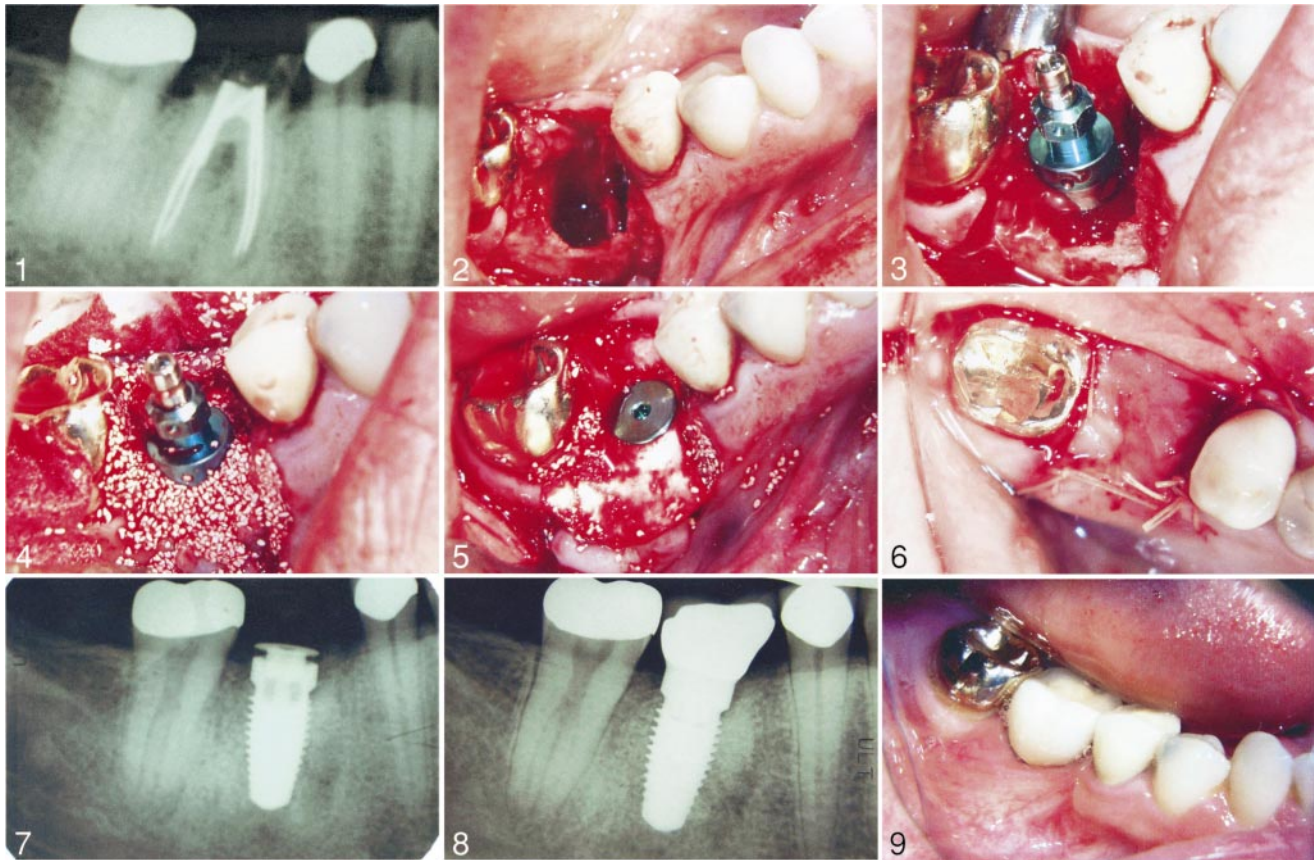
Radiographic view of case 1 preoperatively. FIGURE 2. Clinical view of the extraction socket after the extraction. FIGURE 3. Clinical view of the implant in place. FIGURE 4. Clinical view of the implant with the bone augmentation graft. FIGURE 5. The grafted material around the implant covered with the collagen membrane. FIGURE 6. The buccal and lingual flaps sutured. FIGURE 7. Radiographic view of the implant 3 months after the procedure. FIGURE 8. Radiographic view of the restored implant. FIGURE 9. Clinical view of the restored implant.
